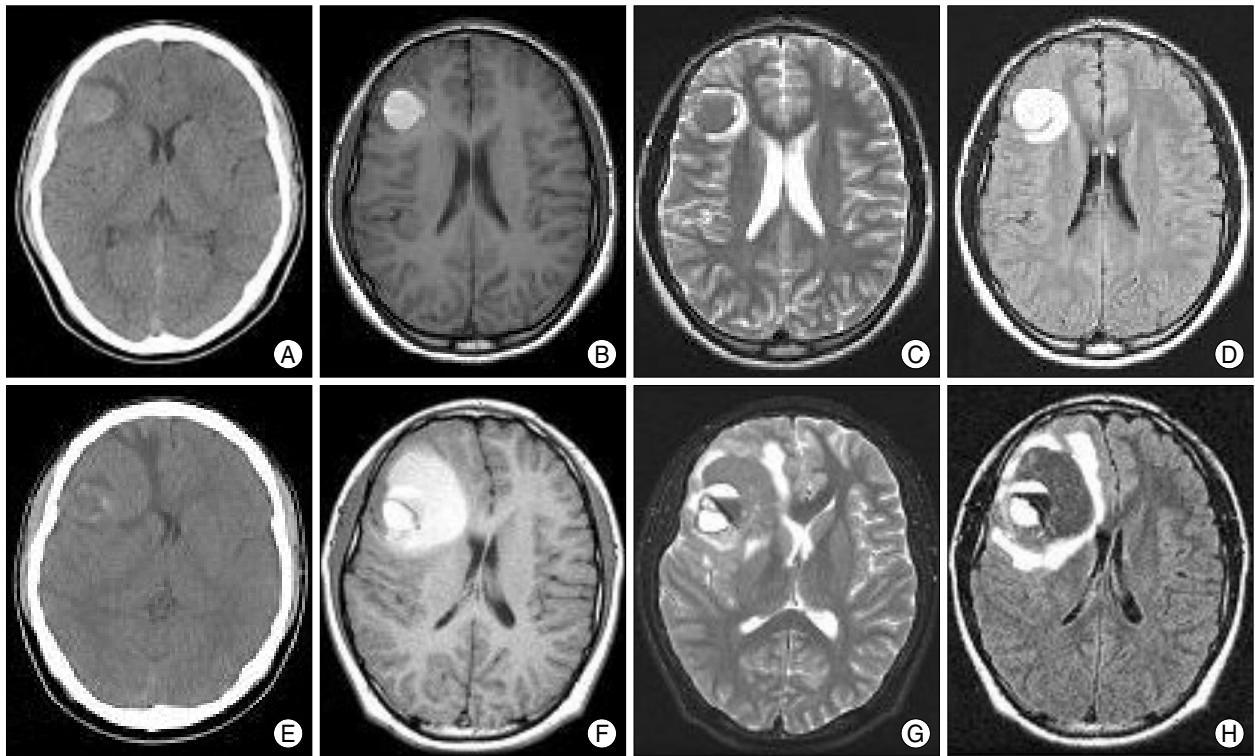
The upper four figures are computed tomography (CT) (A) and magnetic resonance (MR) images (B, C, and D) at first admission with symptoms such as headache and seizure. There is a subacute staged, homogenous round-shaped hemorrhage on the right frontal area. The lower four figures are CT (E) and MR images (F, G, and H) at second admission with increasing intensity of headadche. There is a multiple staged, heterogenous hemorrhage on the same area.
